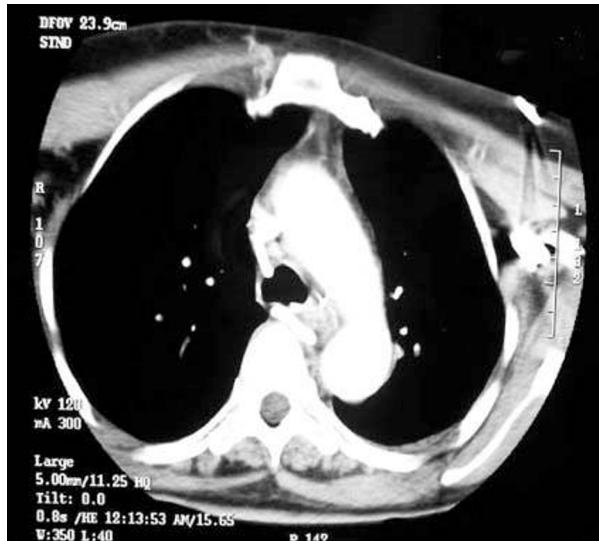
64-year-old woman with implanted venous access device. Chest CT shows the catheter tip in the trachea.
